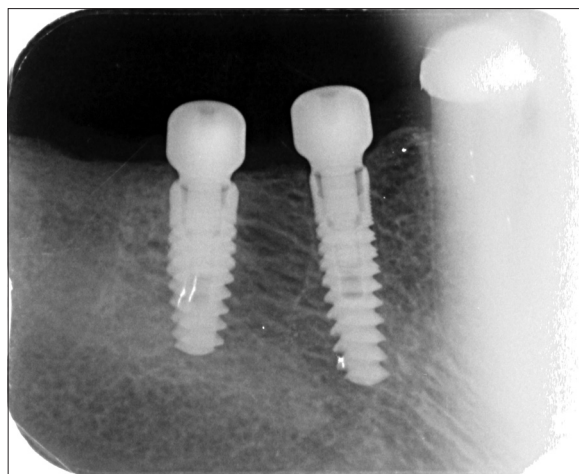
The digital intra-oral periapical image of Case no 5, 6-month postimplant insertion at the time of prosthetic loading showing good osseointegration and maintained cervical bone level
